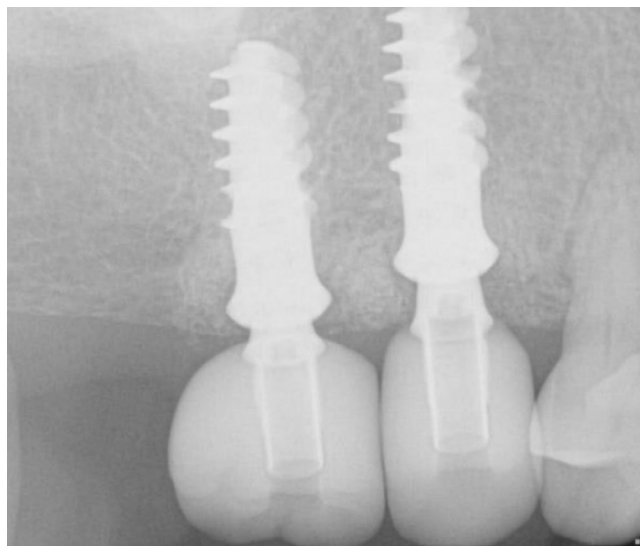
Periapical radiograph at 1 year follow-up.
